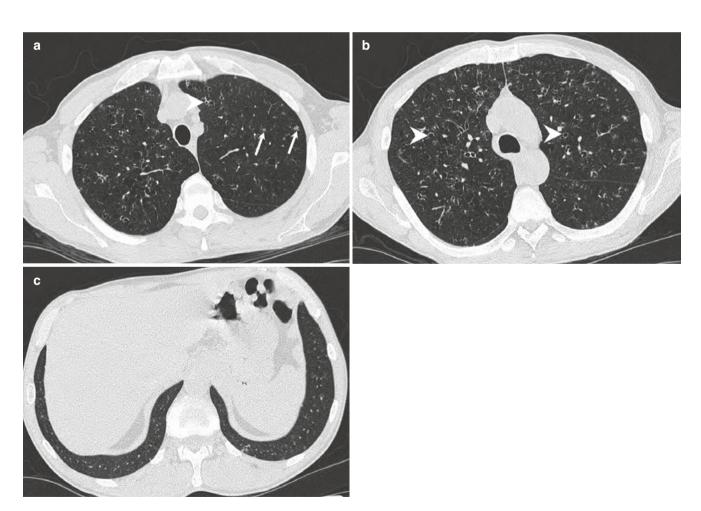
A 59-year-old man with early LCH. (a, b) Axial CT images show nodules (white arrows) along with small cysts with a true wall suggesting that these cysts are cavities in preexisting nodules (arrowheads). (c) Axial image from lung bases shows sparing of costophrenic angles
